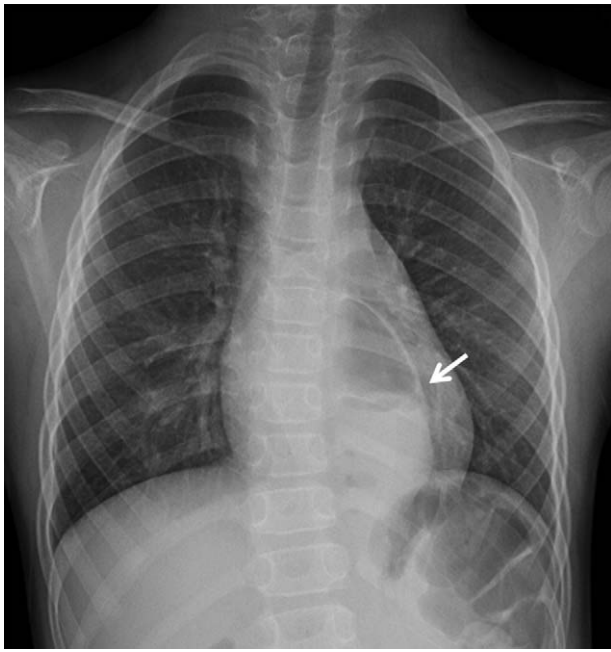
Chest radiograph image of a 6 year-old child who recently developed recurrent vomiting. A 7 × 3 cm sized oval mass-like lesion with internal air-fluid level is located in the posterior paravertebral region (arrow).
